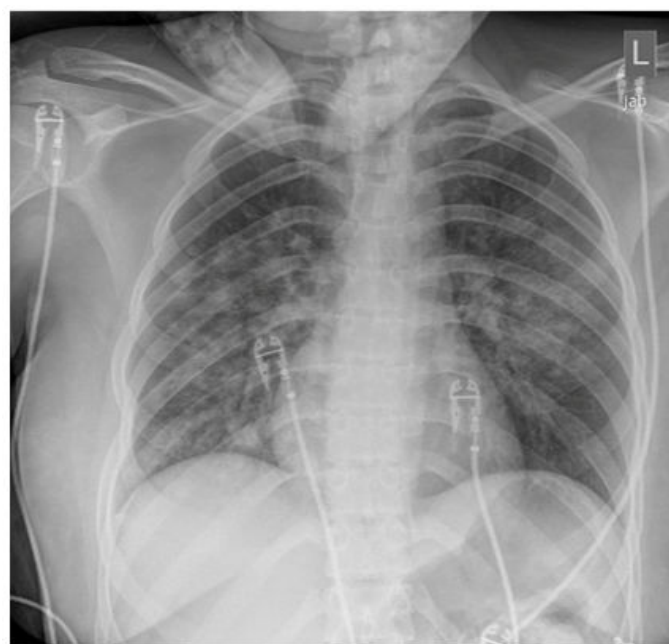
X-ray chest PA View showing negative pulmonary edema due to sever laryngospasm.
